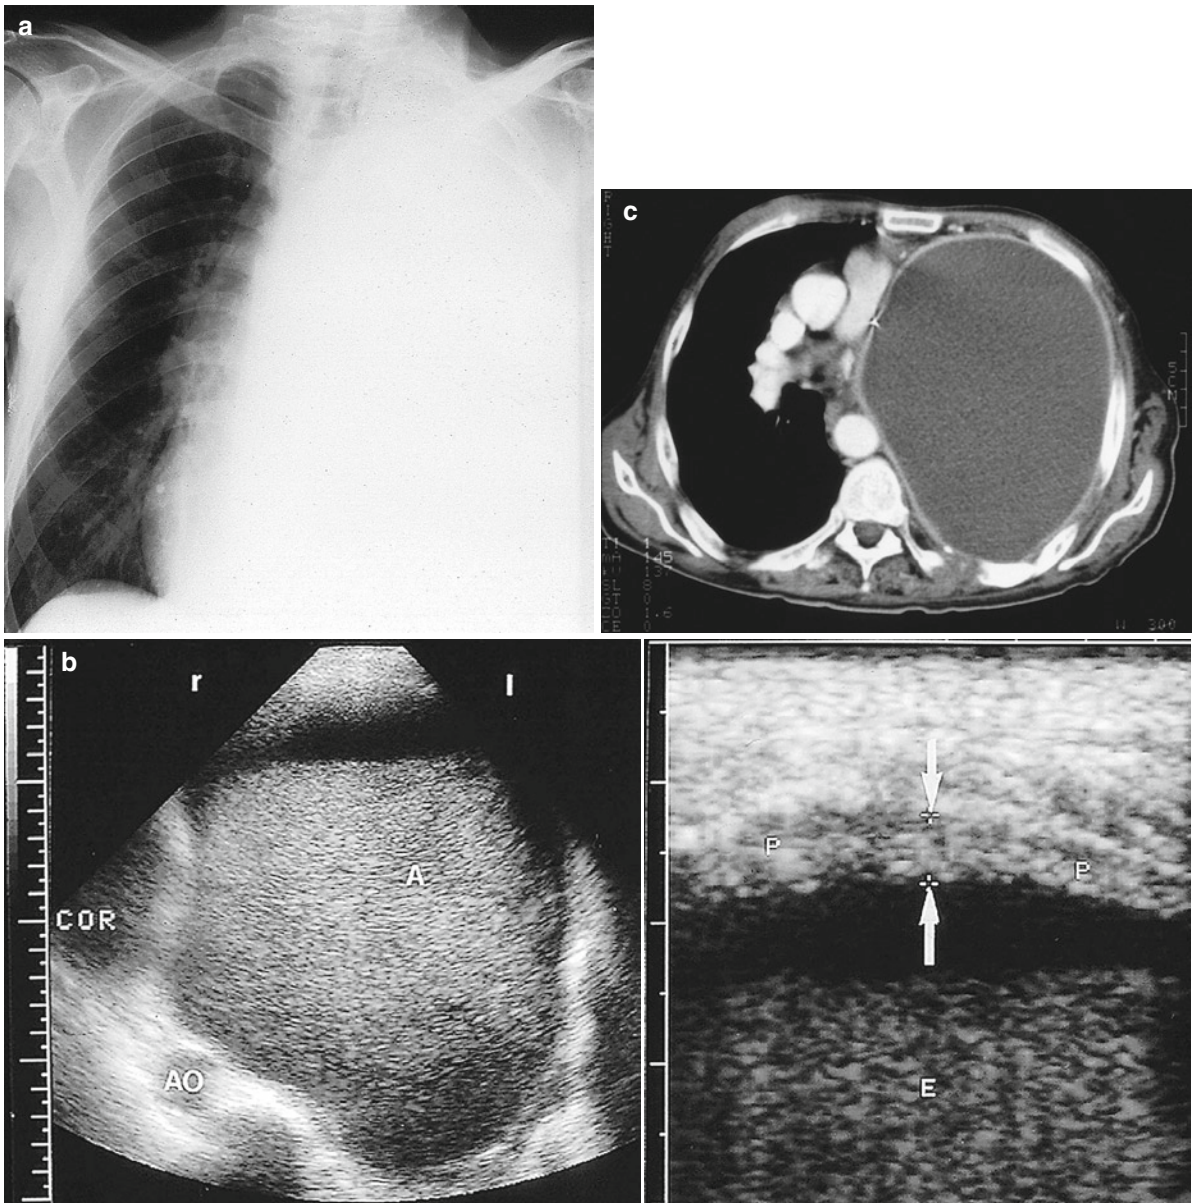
A 60-year-old man with bronchial carcinoma. (a) Chest radiograph. Nearly complete lung opacity on the right side. (b) Ultrasonography. The lateral intercostal ultrasound beam
